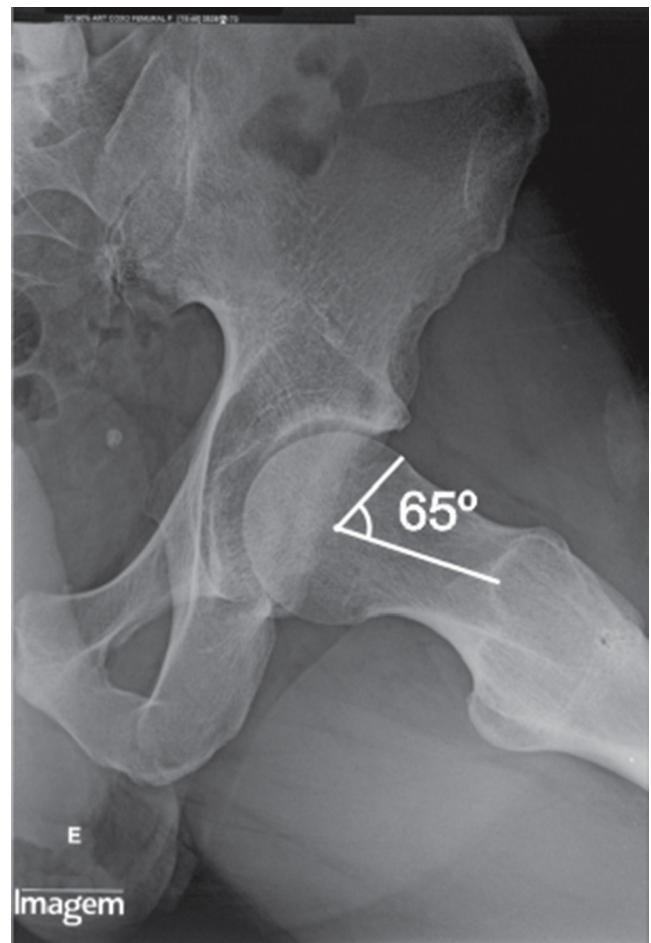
The same patient from the previous figure. Profile radiography of the femoral neck, with a measurement of the alpha angle. The center of the femoral head is determined. From this point, a line is drawn until the limit of the spherical portion of the femoral head and another line is drawn along the center of the neck. The angle between the two straight lines is the alpha angle (normal 50°).
